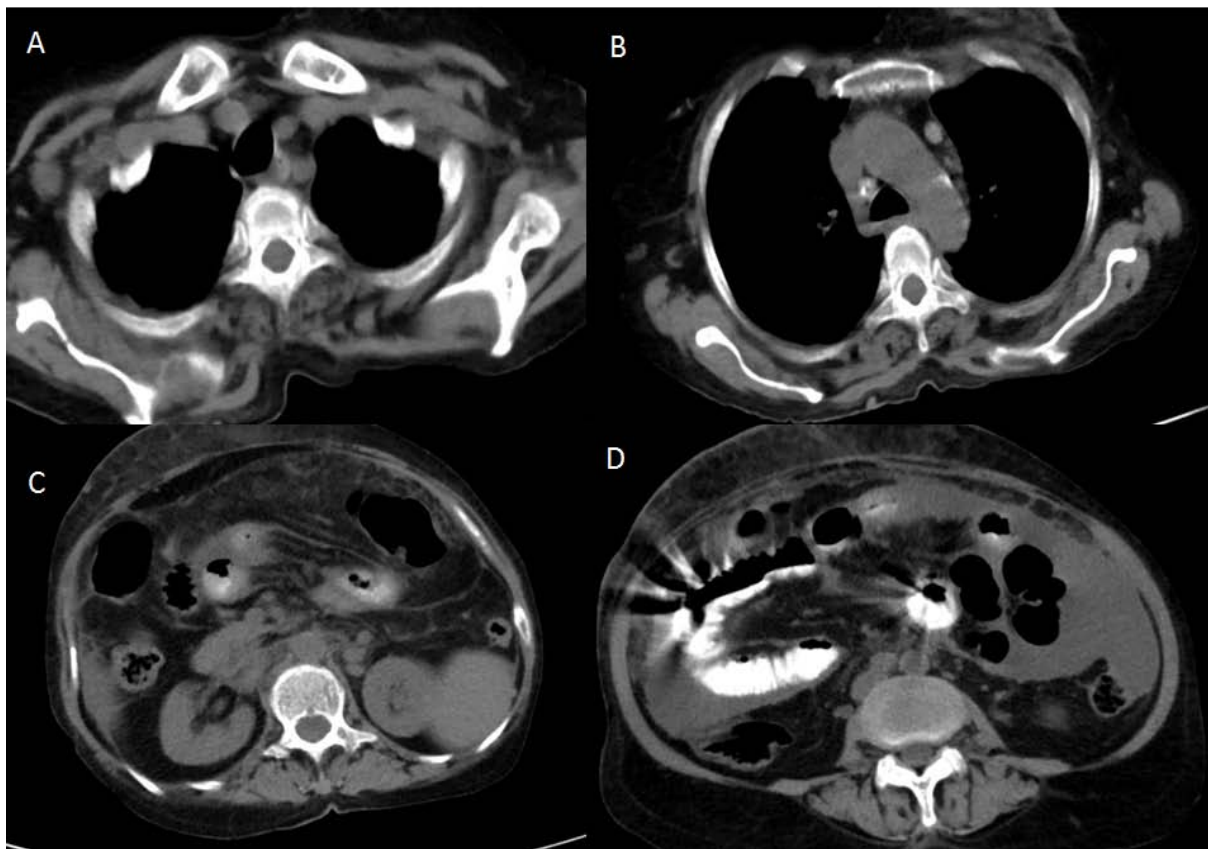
Plain CT thorax (A, B) - showing lymph nodes in right axilla (A) and prevascular space (B).
